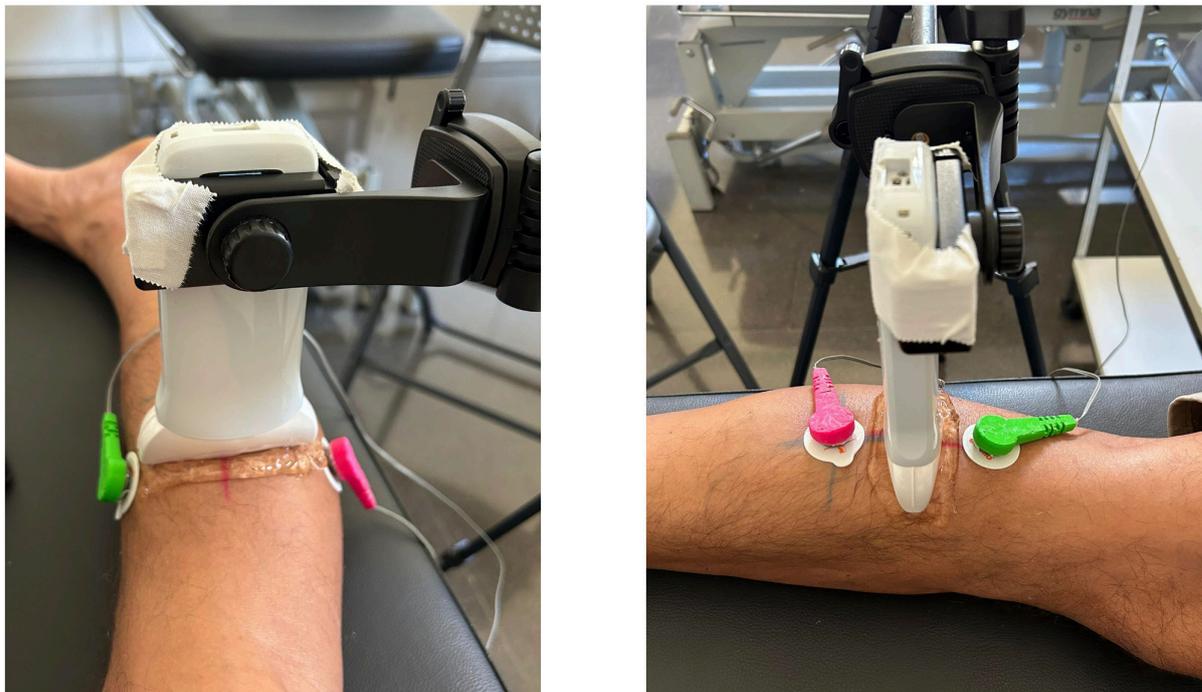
Ultrasound probe in transverse planes with electrodes placed longitudinally on each side (Figure 4A) and with electrodes aligned transversely along the probe width (Figure 4B).
